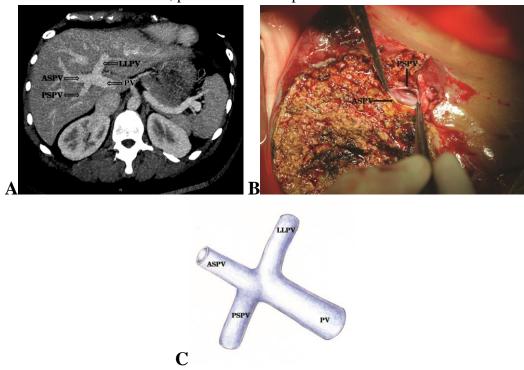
Anatomical subtype B1: A. (CT image); B. (Photo); C.
